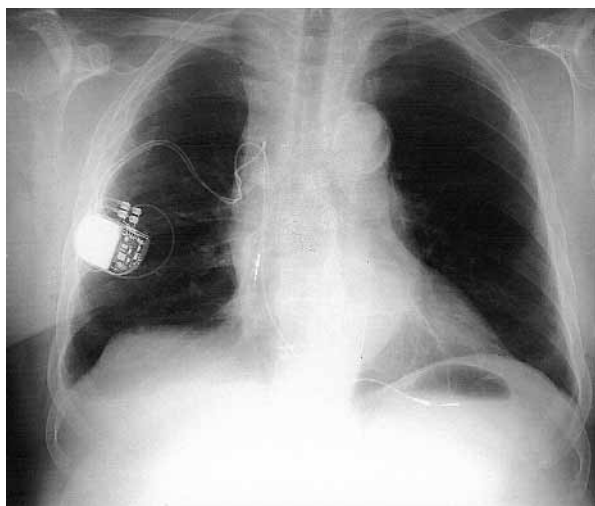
Postoperative chest x-ray film. Note the pacemaker lead position: entrance in the superior vena cava at the azygos vein level. The ventricular lead is positioned in the right ventricular apex and the helix of the atrial lead at the opening of the inferior vena cava in the right atrium.
